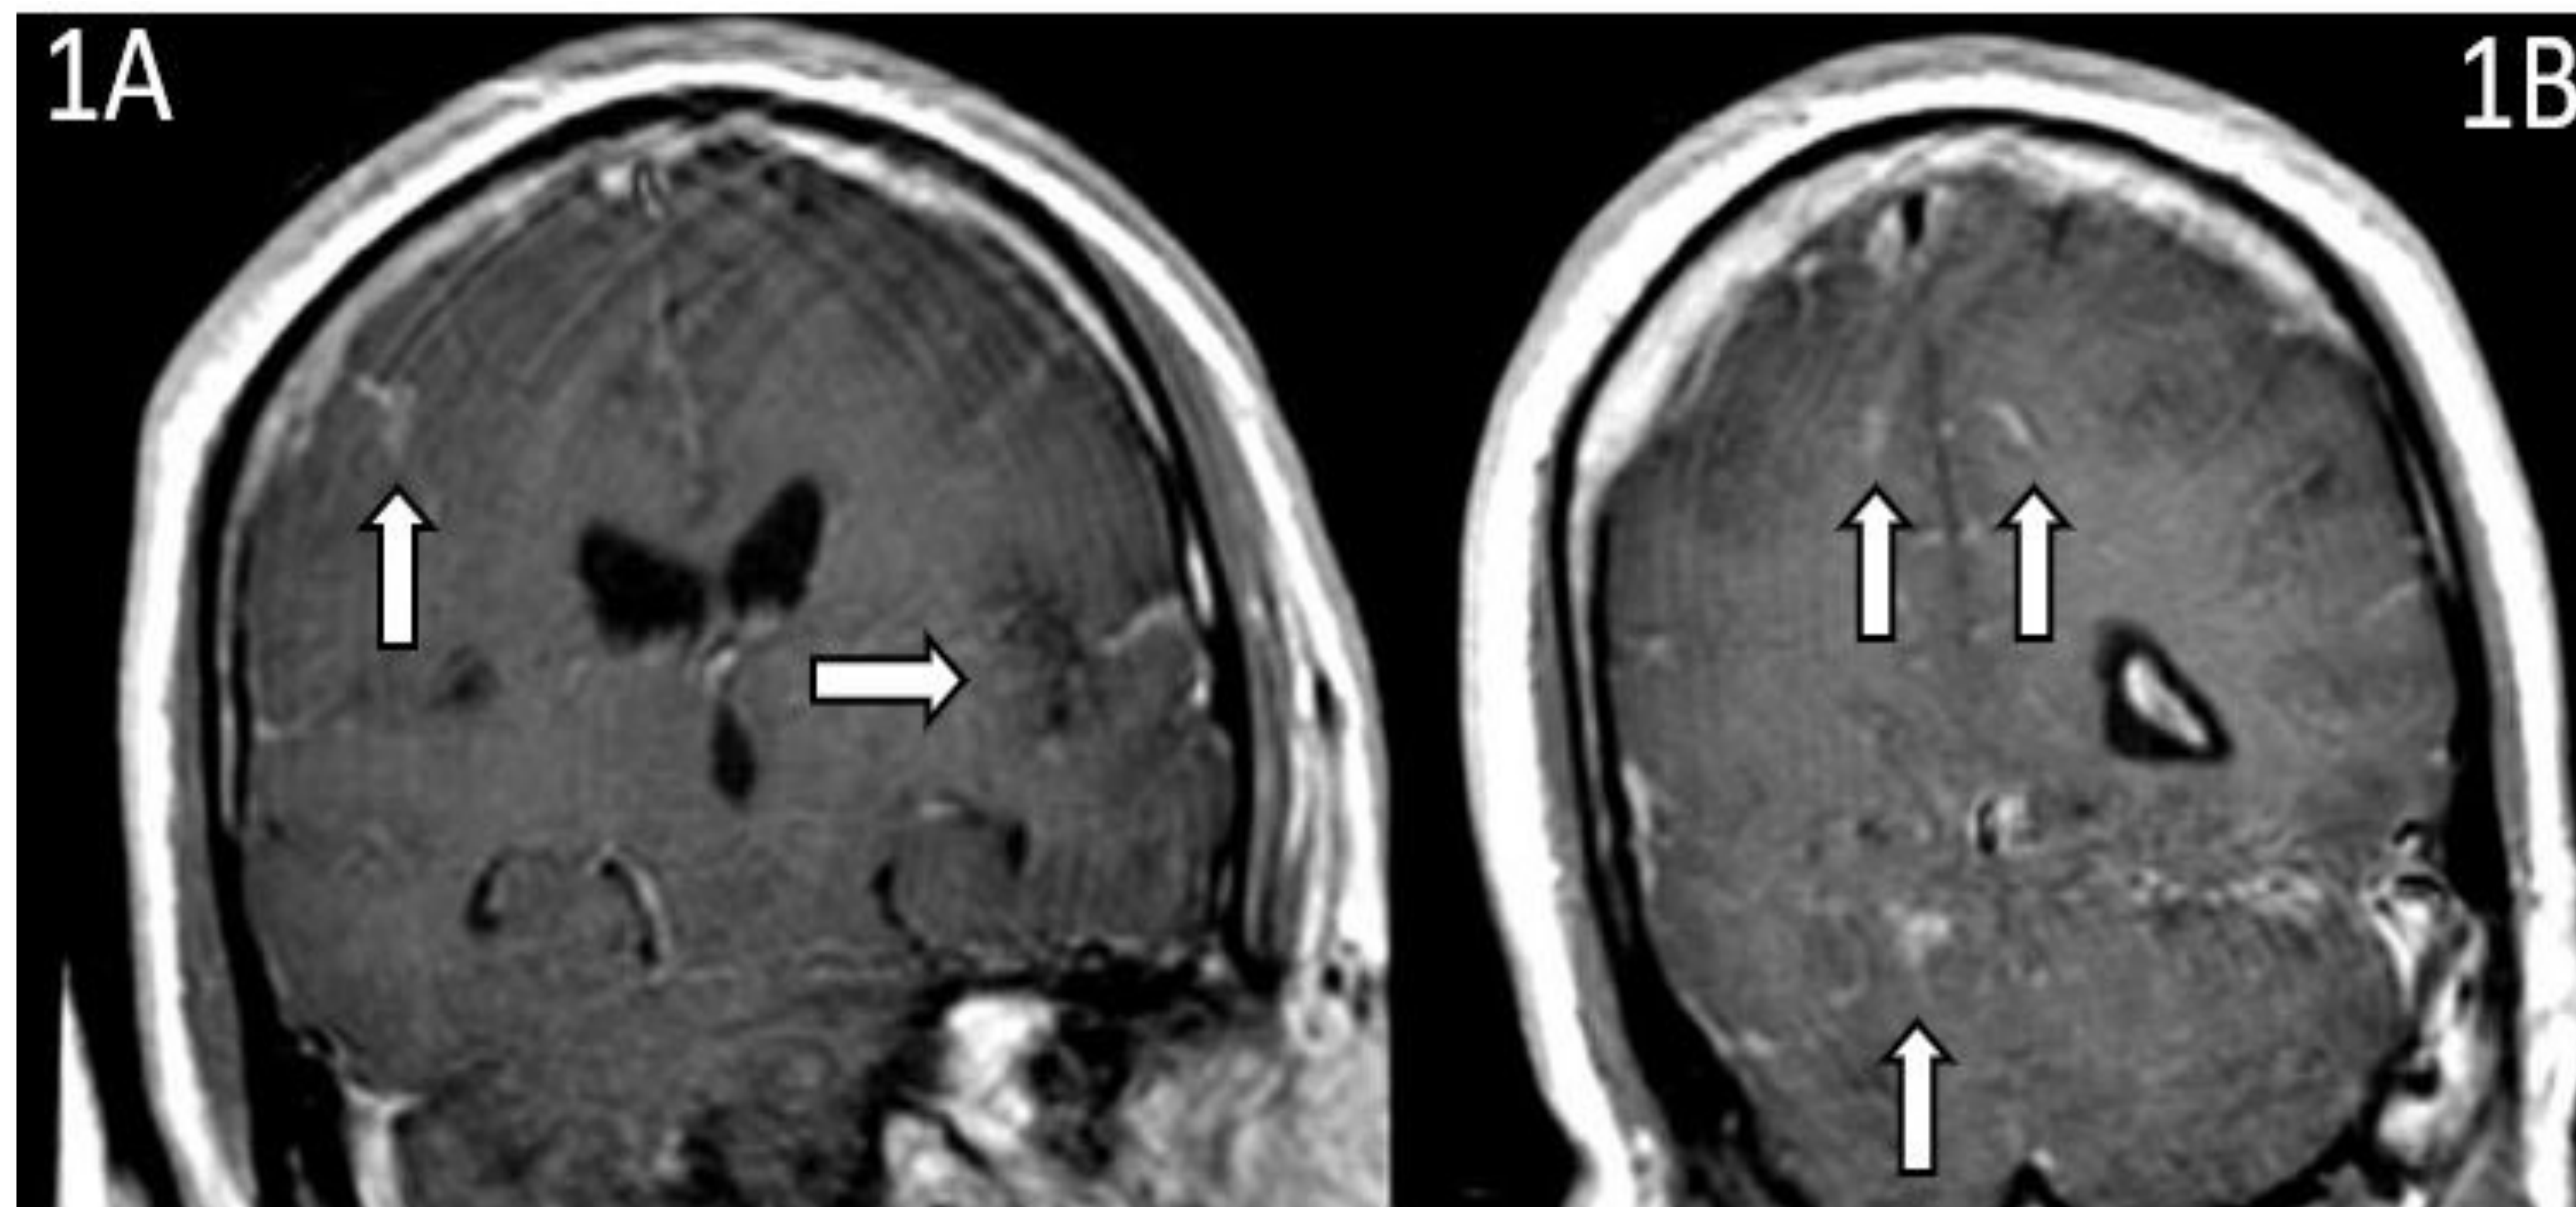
Coronal View MRI Demonstrating Leptomeningeal Enhancement in the Cerebrum and Cerebellum
